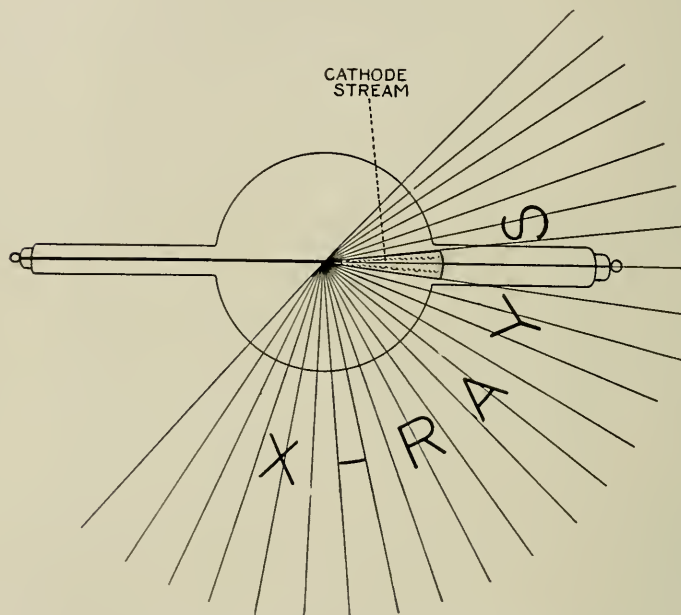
Showing the direct X-ray and the cathode stream.
